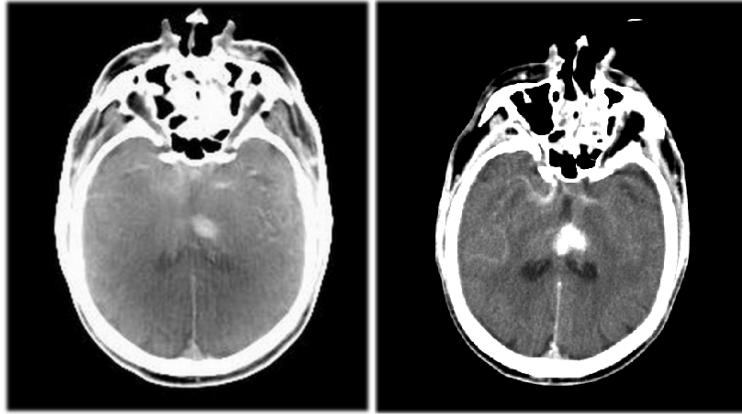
Comparison 3D-RX (left) with CT (right) for imaging of fresh intra-cerebral bleeding. (Data courtesy of Prof. Moret, Fondation Ophthalmologique de Rothschild, Paris, France).
